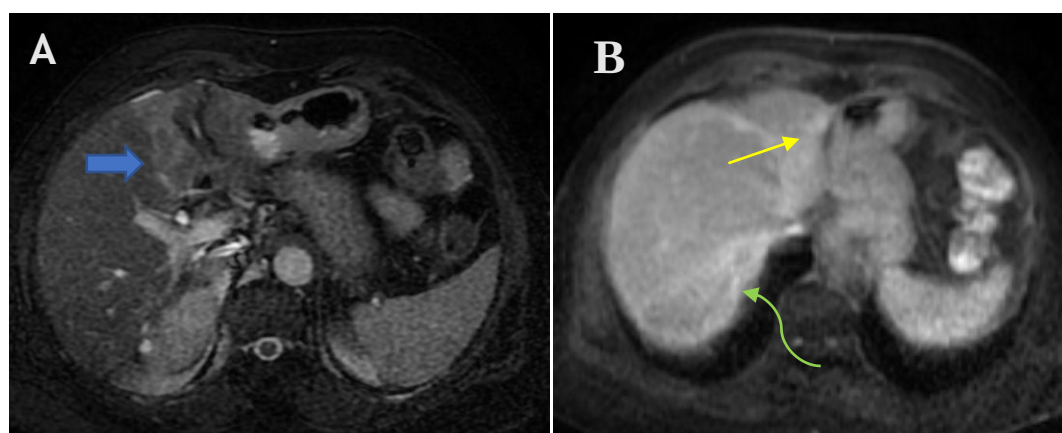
& 1B: A seventy-three-year-old female, presented with abdominal pain; Axial T2 W and post contrast axial T1 W MRI of the abdomen at the level of the liver shows ill defined T2 hyperintense lesion (block arrow) involving the left lobe of the liver which is seen to extend upto the capsule of the liver showing persistent progressive contrast enhancement (yellow arrow). Similar enhancing ill defined lesion is also seen involving the subcapsular region of right lobe of liver (curved arrow) involving segment VII extending upto the hilum of the liver.
